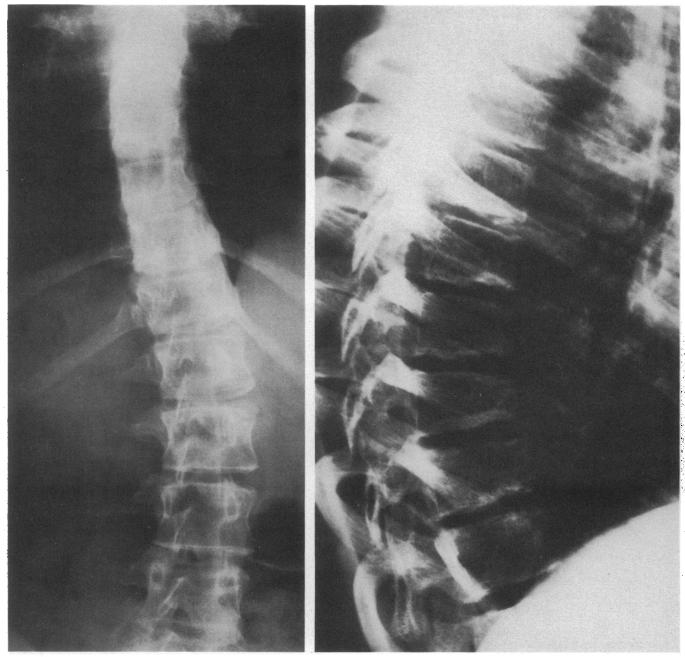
(a) PA radiograph a patient with Scheuermann's disease showing an "idiopathic-type" scoliosis below the area of kyphosis. (b) Lateral radiograph of the thoracic spine of the same patient showing an increased thoracic kyphosis.
